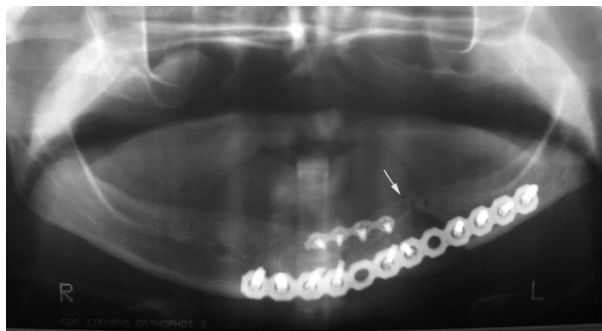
Case 3. Panoramic radiograph with arrow at the bony defect in the left mandible 3 months after repair of a comminuted mandible fracture.
